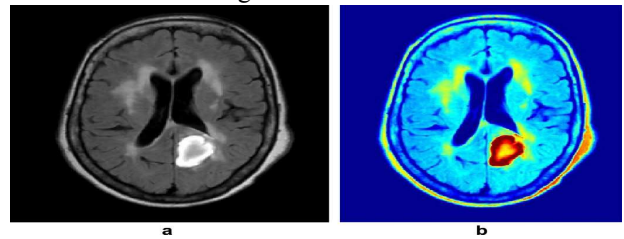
Original MRI spin-density brain images, (a) gray-level image and (b) Color image
